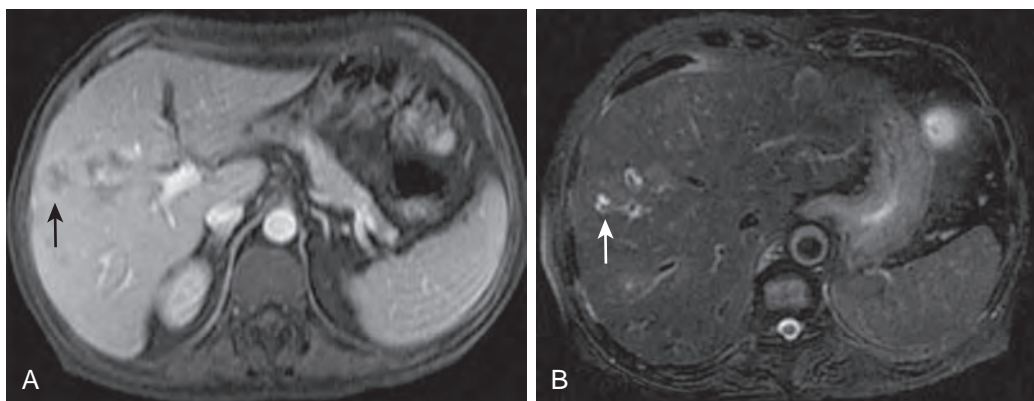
Fasciola hepatica: MRI findings. A patient with *Fasciola hepatica* (arrow). Note the branching subcapsular peripheral lesions on T2-weighted (A) and portal venous phase (B) images.
